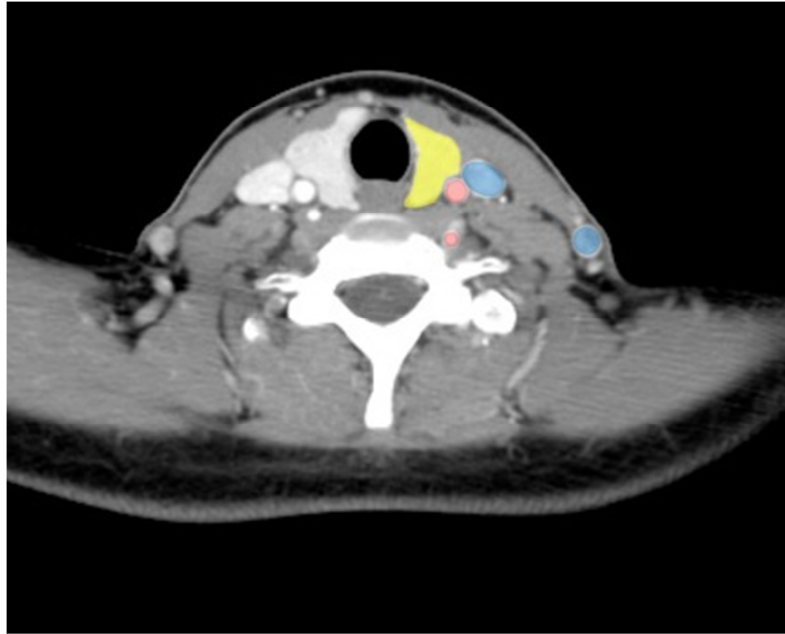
²⁹: CT image showing relationship of vessels in the neck.
